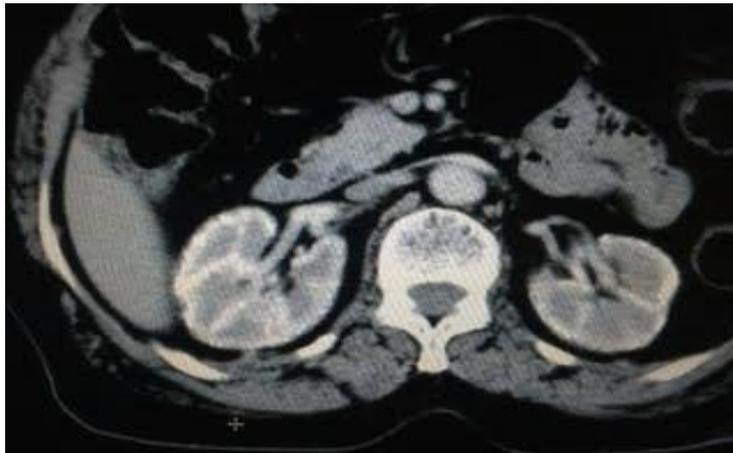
CT abdomen axial view - post contrast
